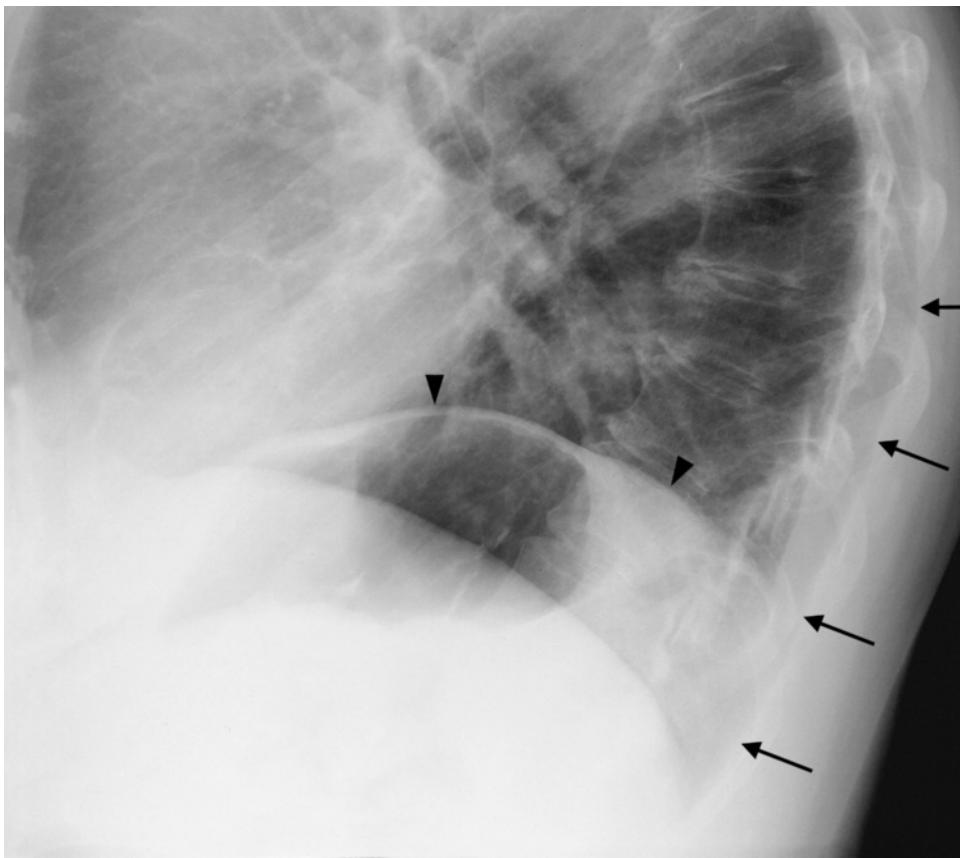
Pleura in relation to the ribs. The pleura passes through the apices of the posterior rib arches (black arrows) on the lateral radiograph. The pleura can be traced along the respective ribs (here the right ones) as far as the costophrenic angle. The diaphragmatic crus superior to the clearly identifiable stomach bubble is the left one (black arrowheads). This clearly defines the posterior costophrenic angle (patient with senile emphysema and gibbus).
